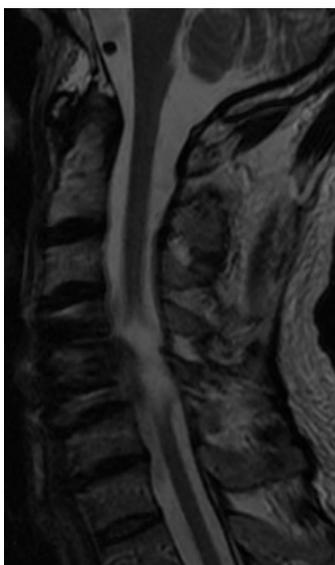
Sagittal T2 MRI in a 43y old male tetraplegic patient 5 years after cervical C4 spinal trauma showing complete transection of the spinal cord.
